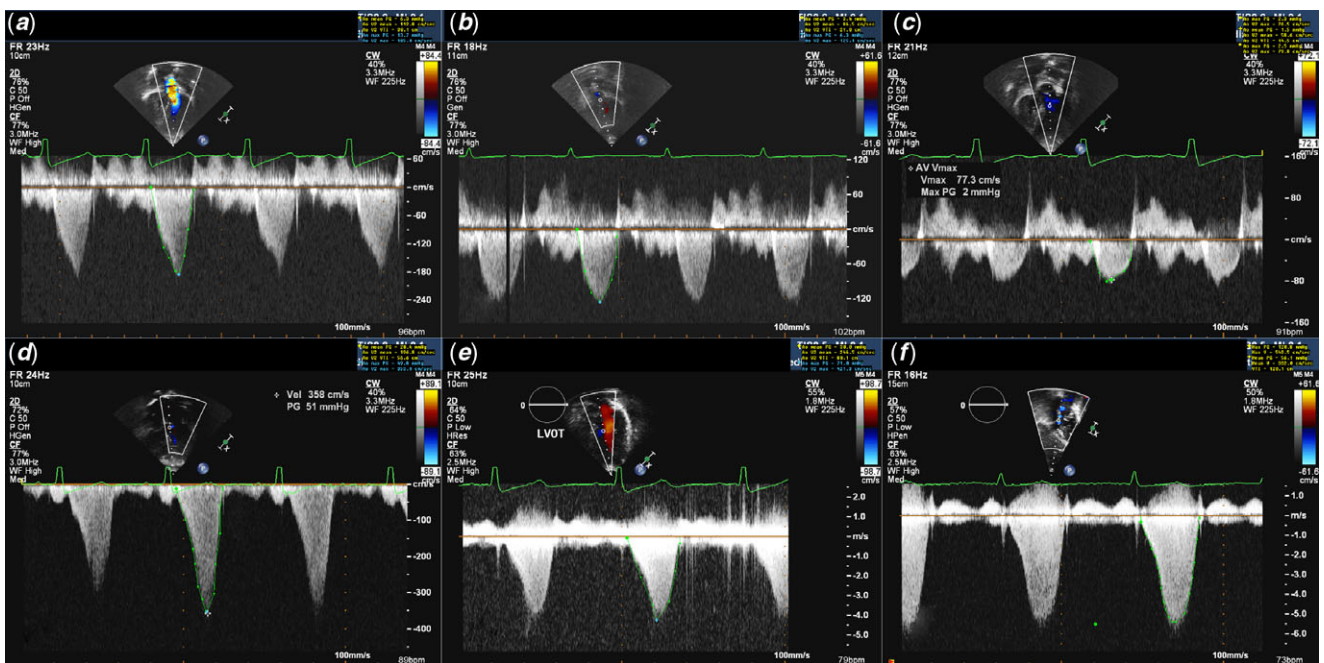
Longitudinal changes in Doppler echocardiogram across systemic ventricular outflow tract. (a) pre-Fontan procedure (a peak pressure gradient of 13 mmHg), (b) at the time of discharge after FP (6 mmHg), (c) 3 months after FP (2 mmHg), (d) 6 months after FP (50 mmHg), (e) at 4 years of age (71 mmHg), (f) at 5 years of age (120 mmHg).
